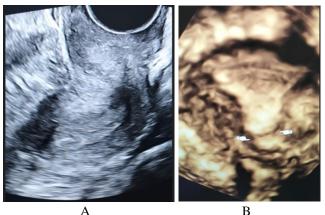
A. 2D ultrasound showing exaggerated uterine cervical fold and which is well delineated on the corresponding 3D image (B hand pointers)
